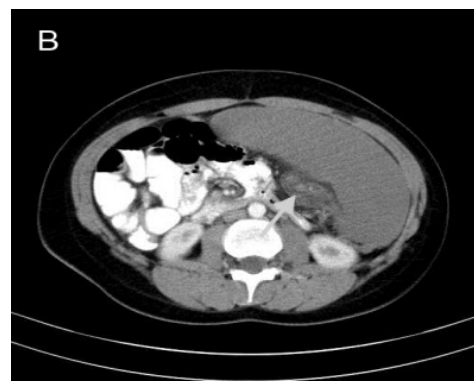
Contrast-enhanced abdominal CT in axial showed an absence of the spleen in the left upper quadrant and whirled sign; a whirled appearance of hyperdense non-enhancing splenic vessels
